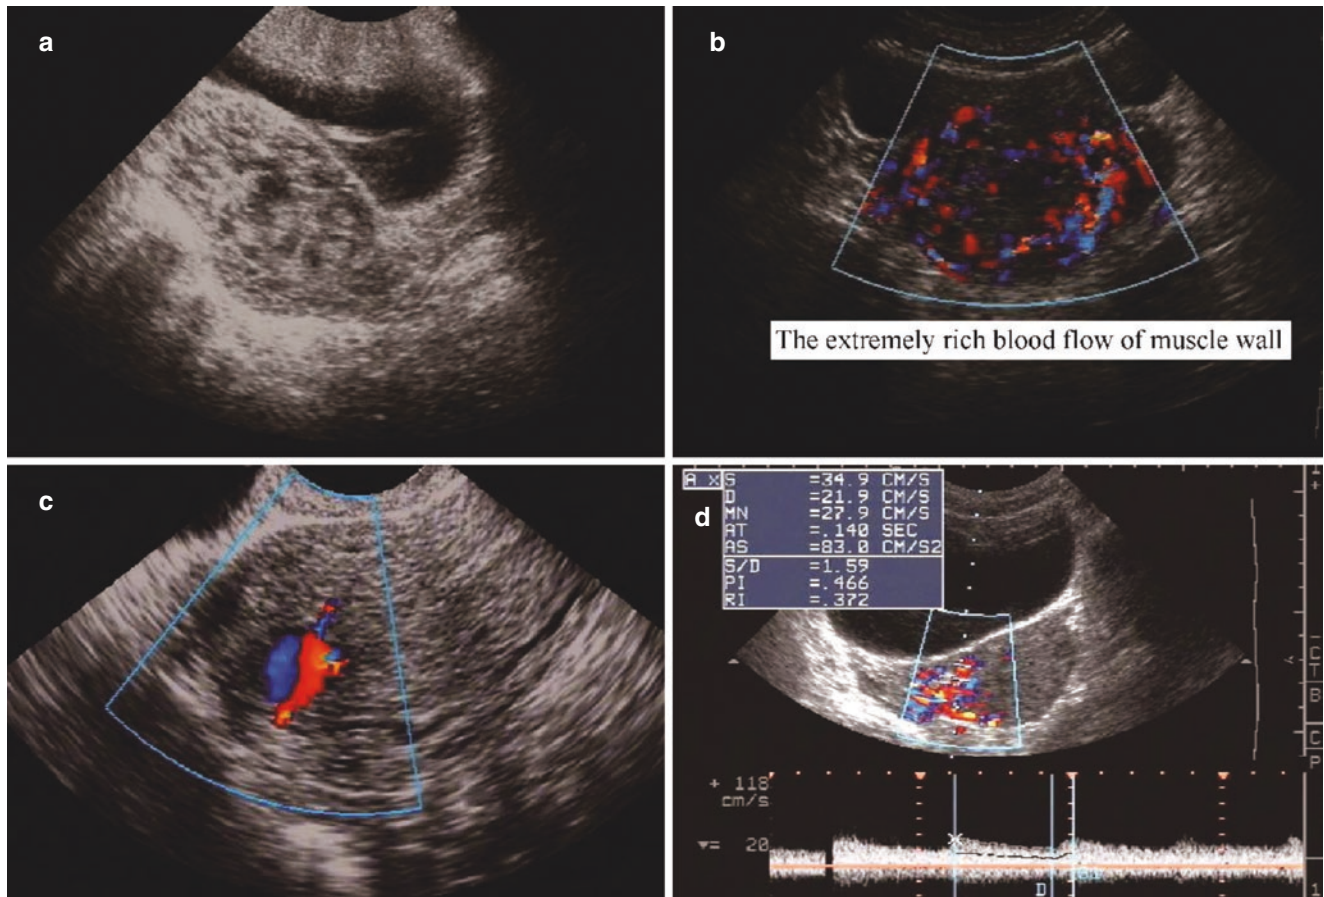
Malignant trophoblastic tumor. 7 months after the operation of hydatidiform mole, a 32 years old patient is diagnosed as invasive hydatidiform mole, with irregular vaginal bleeding and high hCG level. (a). Ultrasound scan shows the enlarged uterus without endometrial echo, and the muscle wall represents “honeycomb” echo; (b). The
